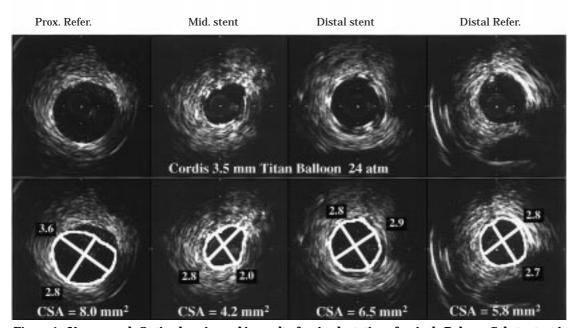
Upper panel: Optimal angiographic result after implantation of a single Palmaz–Schatz stent in the mid-left anterior descending coronary artery. Lower panels: Despite high pressure balloon dilatation with a large balloon, a segment of incomplete expansion is observed with intracoronary ultrasound within the stent (Mid-stent). CSA = cross-sectional area.
